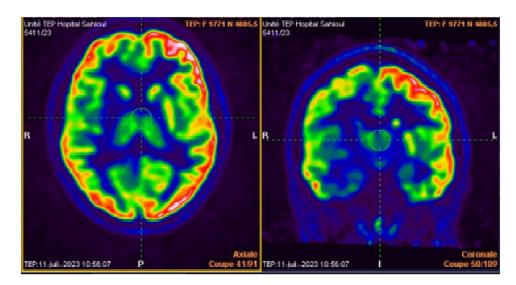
FDG-PET scan demonstrating diffuse, unilateral diffuse hypometabolism in the right frontal, parietal, temporal and occipital lobes, corresponding to the areas of atrophy observed on MRI, as well as within the ipsilateral basal ganglia.
